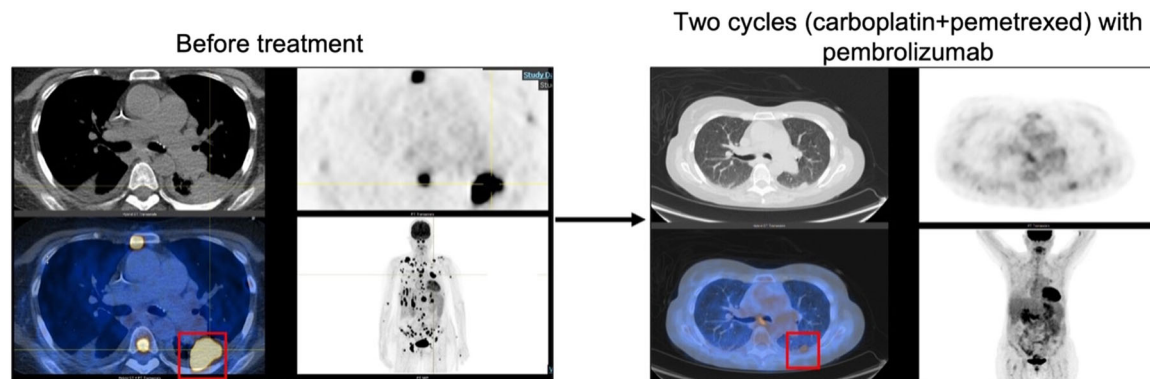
PET/CT imaging revealed a 4 cm lesion (46 SUV) in the posterior aspect of the superior segment of the left lower lobe with multiple hypermetabolic lesions in the liver (largest 2.8 cm, 43 SUV), and widespread osseous disease. After two cycles of carboplatin +pemetrexed (pembrolizumab added in Cycle 2), the lung lesion decreased in size to 1.3 cm (2.7 SUV), and there was no more presence of metastatic disease. The red outline indicates a primary lung adenocarcinoma lesion.
